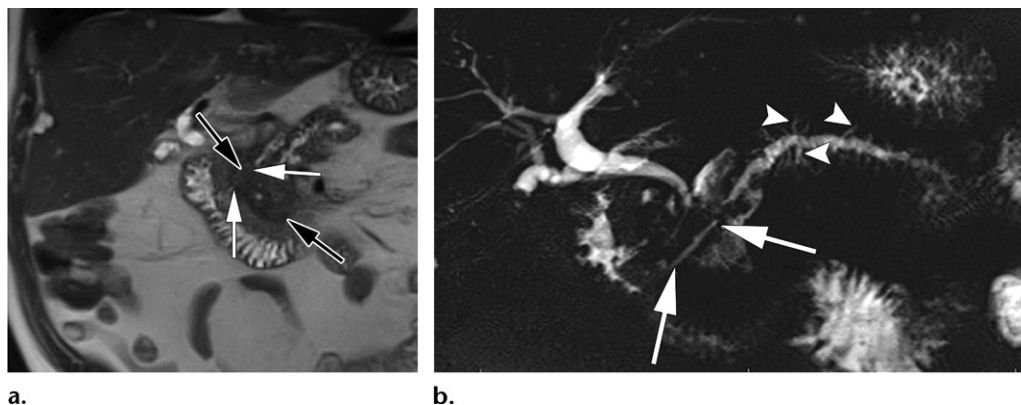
Imaging findings that favor diagnosis of an inflammatory condition (or mass-forming pancreatitis) rather than malignancy. (a) Coronal T2-weighted MR image through the pancreatic head shows a heterogeneous masslike lesion (black arrows). The proximal main pancreatic duct has a decreased caliber and can be seen traversing through the mass (white arrows). (b) MR cholangiopancreatogram clearly shows the narrowed main pancreatic duct in the masslike lesion (arrows), which is consistent with the duct-penetrating sign. Prominent side branches are seen along the course of the distal pancreatic duct (arrowheads).
